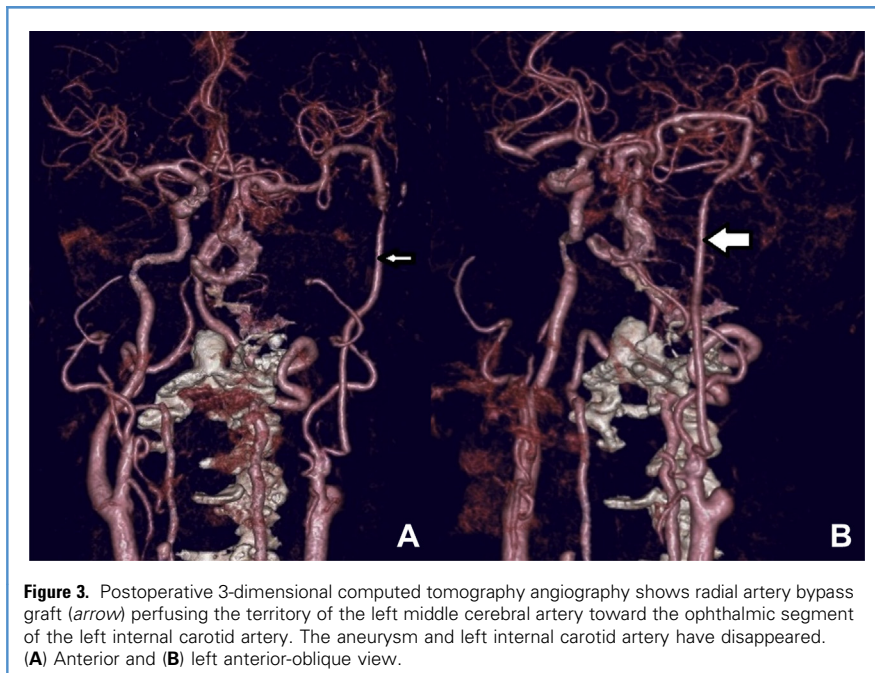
Postoperative 3-dimensional computed tomography angiography shows radial artery bypass graft (arrow) perfusing the territory of the left middle cerebral artery toward the ophthalmic segment of the left internal carotid artery. The aneurysm and left internal carotid artery have disappeared. (A) Anterior and (B) left anterior-oblique view.
